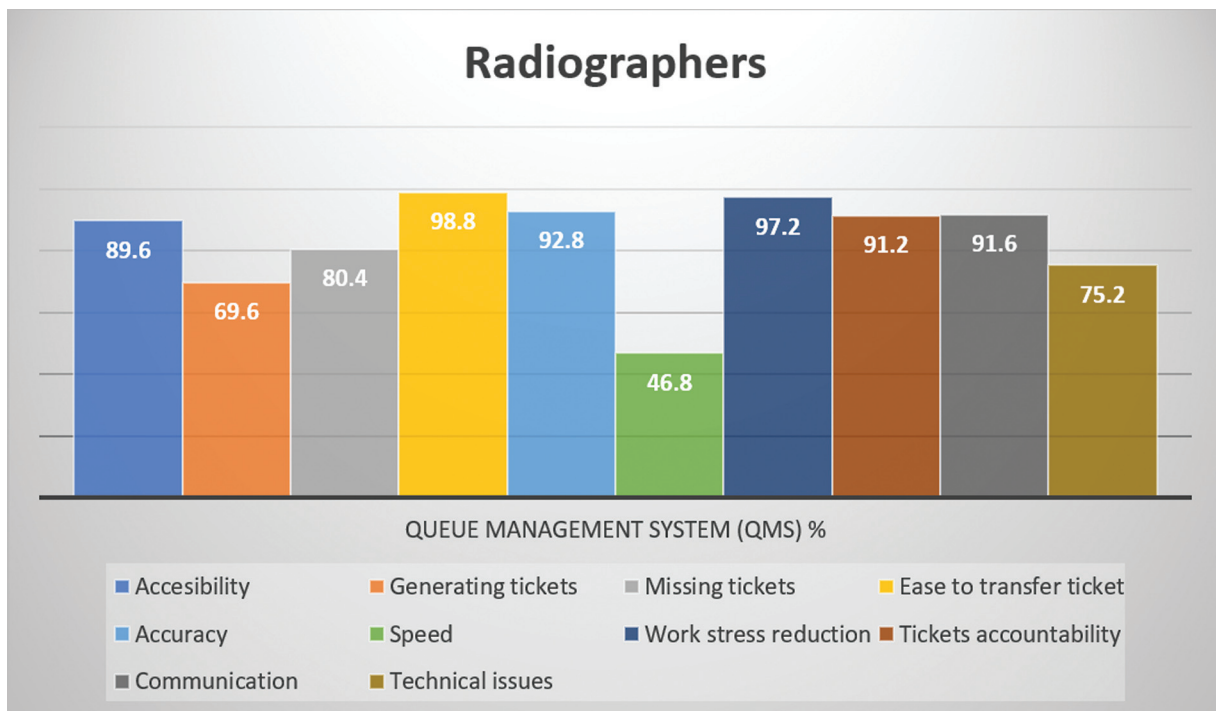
Overall responses obtained from radiographers expressed as percentage. Most notably is the fact that while all assessed parameters surpassed 50% pass mark, speed recorded 46.8%.
